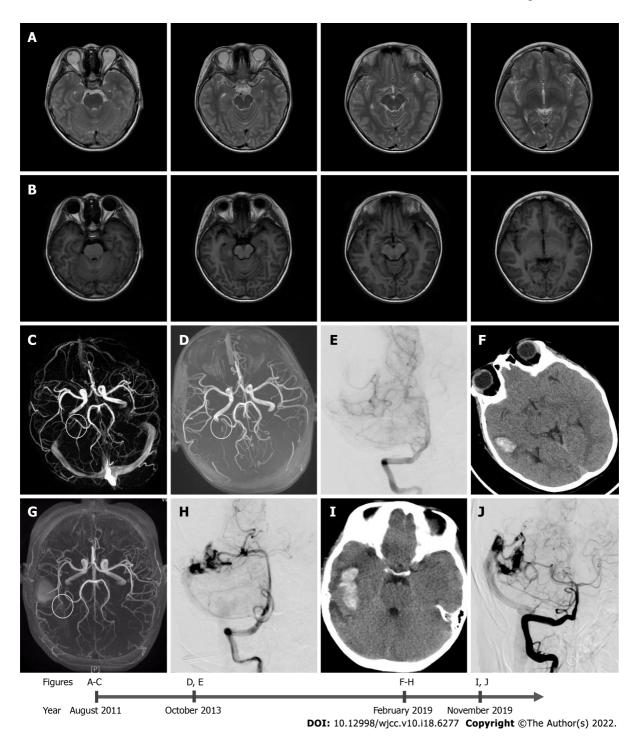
Diagnostic images from August 2011 to November 2019. A-C: T1 (A) and T2 (B) weighted images of magnetic resonance imaging, and (C) magnetic resonance angiography (MRA) done in August 2011, at the age of 5 years and 2 mo. There is no evidence of vascular lesion; D and E: The results of (D) MRA and (E) the first anteroposterior digital subtraction angiography (DSA) performed in October 2013, indicating de novo arteriovenous malformation; F-H: The results of (F) the head computed tomography (CT) scan, (G) MRA, and (H) the second DSA, which were performed in February 2019; I and J: Results from (I) the post-hemorrhage non-contrast head CT scan depicting blood in the right temporal lobe and (J) the third DSA, which were performed in November 2019.
